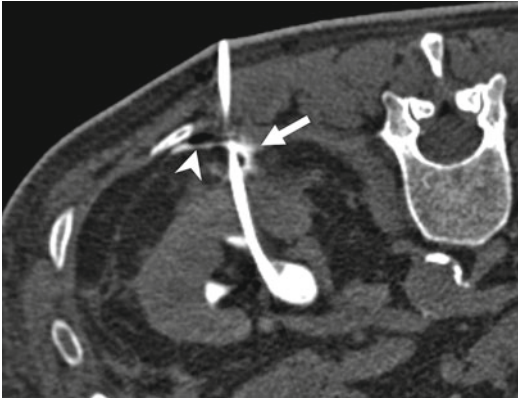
Control CT scan after successful placement of the drainage catheter. Some contrast media (*arrow*) and a little air (*arrowhead*) are visible in the perirenal fatty tissue. This extravasation along the drainage catheter is self-limiting and need no further action as long as adequate drainage is provided
